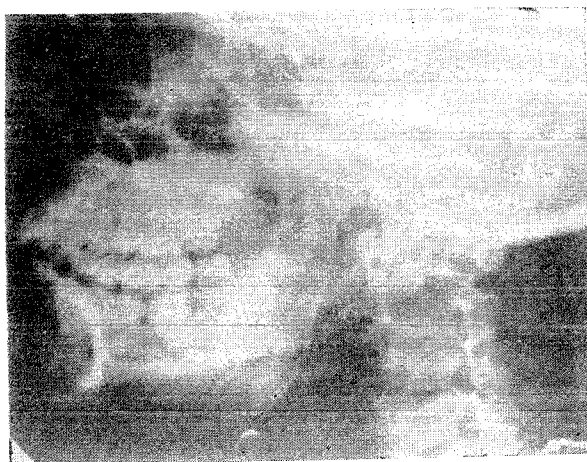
Left lateral x-ray of the mandible.
